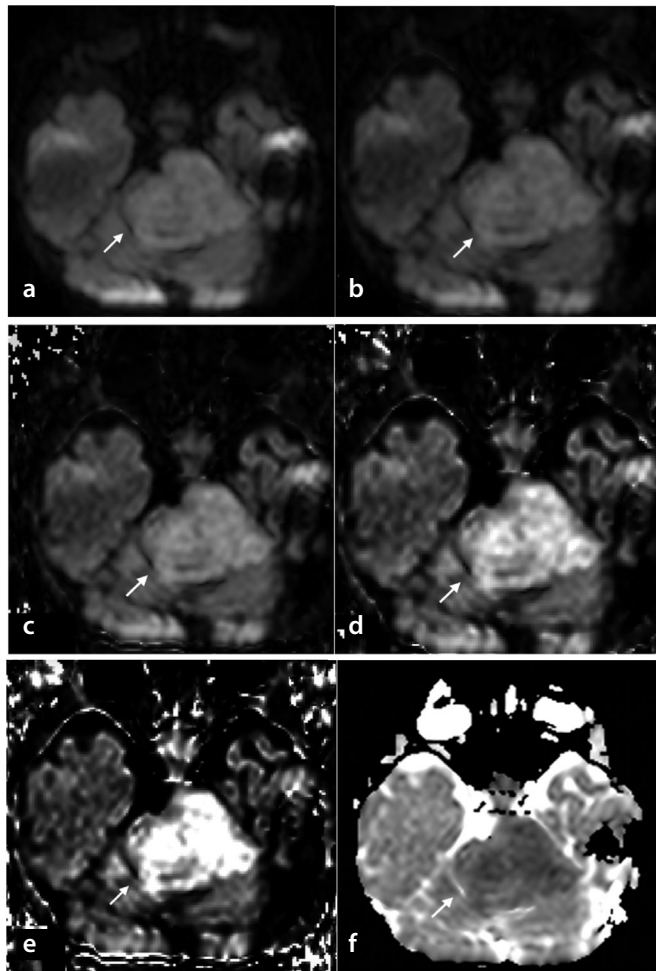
A 13-year-old female with medulloblastoma. (a) Diffusion-weighted imaging (DWI)₁₀₀₀ (b) computed DWI (cDWI)₁₅₀₀ (c) cDWI₂₀₀₀ (d) cDWI₃₀₀₀ (e) cDWI₅₀₀₀ and (f) apparent diffusion coefficient (ADC)₁₀₀₀ maps. In the mass located in the 4th ventricle, indicated by the arrow, as the b-values increase, the signal becomes evident in the tumor tissue, whereas a decrease in the signal is observed in the parenchyma. In addition, a low signal is observed in the parenchyma in the ADC₁₀₀₀ maps (f).
